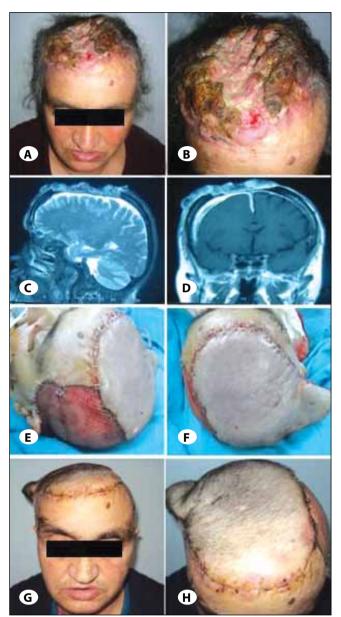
A) 61 years old woman with invasive Squamous cell cancer. B) Vertex view of the patient showing widely tumor invasion of the scalp. C) Sagittal view of cranial MRI showing the tumor invading duramater. D) Coronal view of cranial MRI. E,F) Peroperative view of the patient showing the transposed flap (18X14cm) based on right postauricular region and donor site closure with split skin graft. G,H) Postoperative third week view of the patient.
